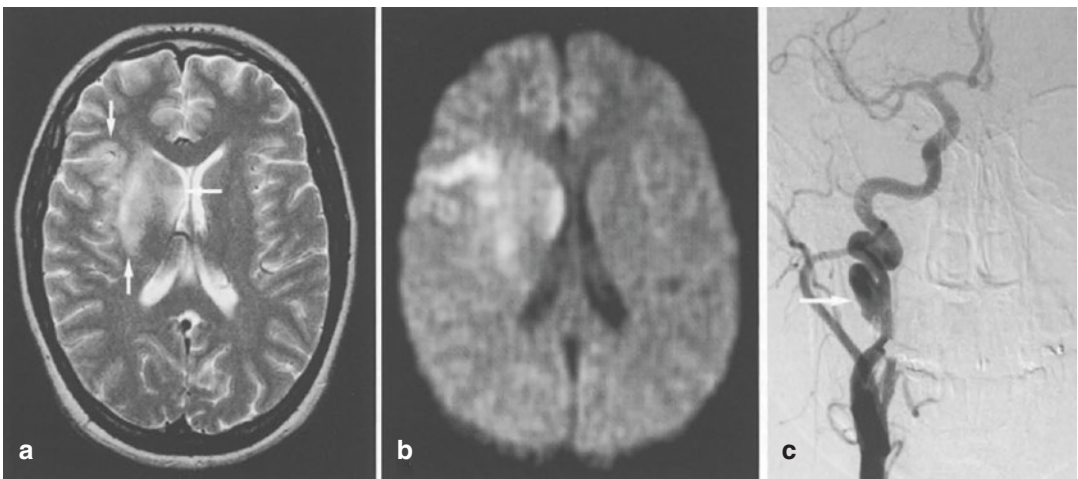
(a–c) Cerebral infarction after carotid artery dissection with pseudoaneurysm in a 20-year-old female patient after a motor vehicle accident. (a) T2-weighted image shows hyperintense lesions in the right middle cerebral artery territory including the right basal ganglia
